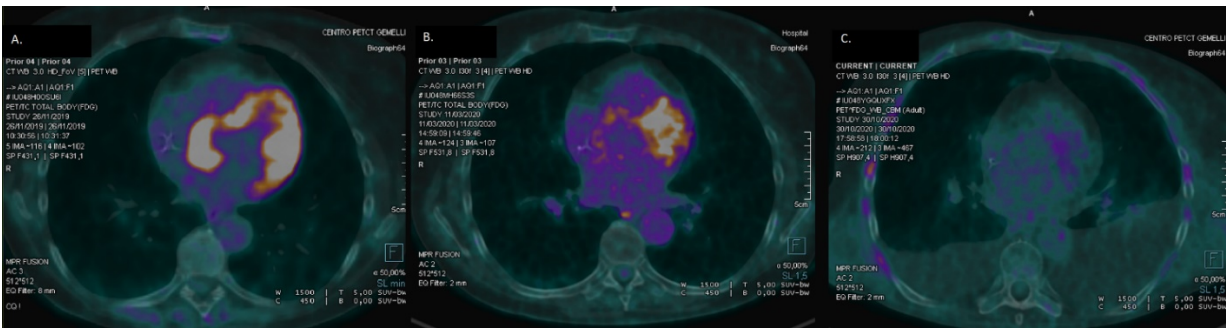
¹⁸F-FDG PET-CT scan: staging (A), one month (B), and eight months (C) after RT re-evaluation
